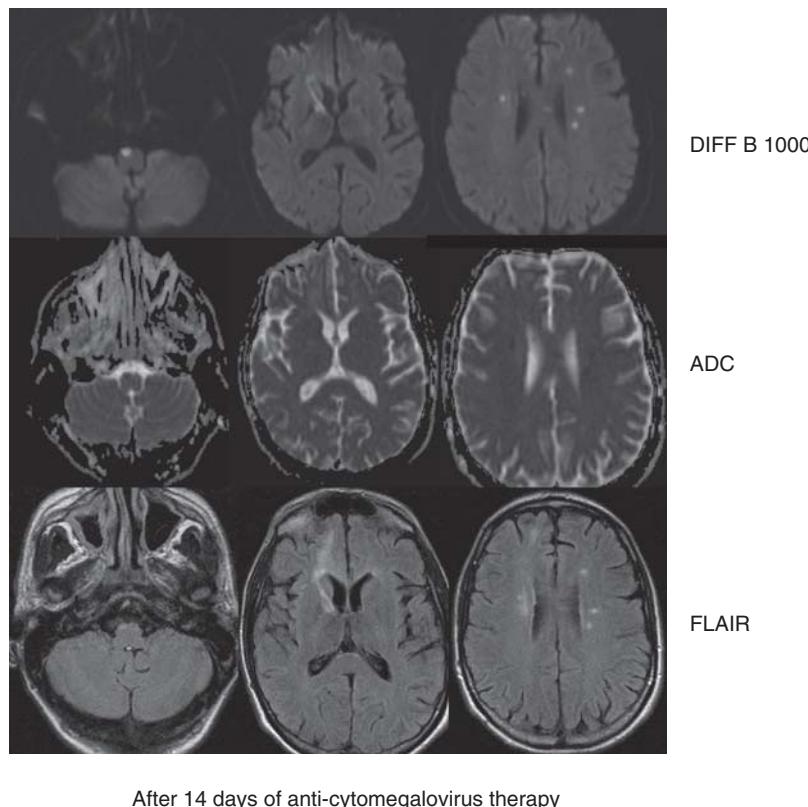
Magnetic resonance imaging shows interval evolution with decreasing conspicuity of the diffusion abnormality especially the ADC map. There are no new areas of suspected infarction again supporting a monophasic process.
